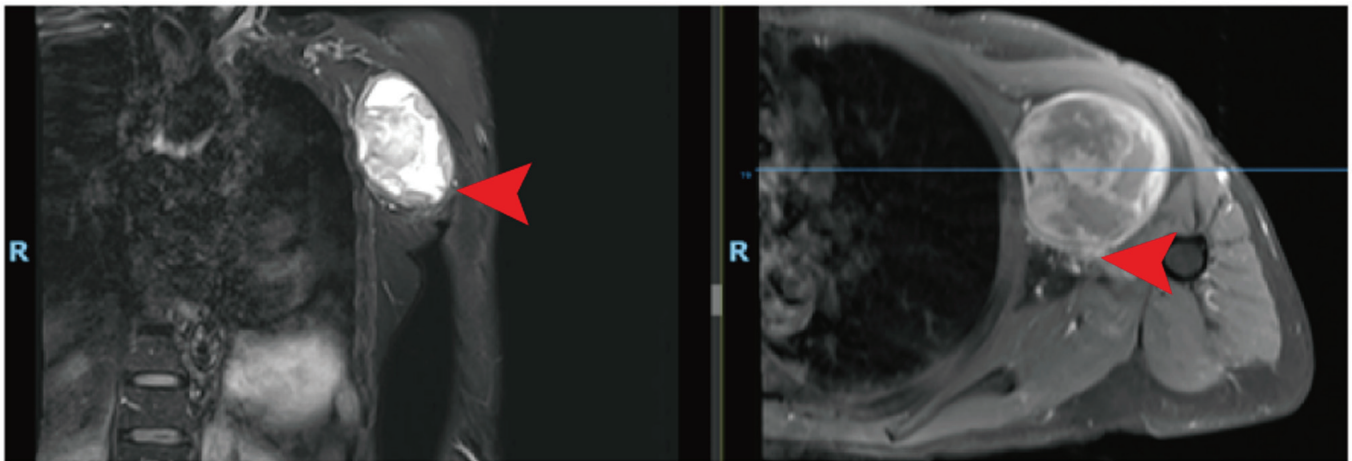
Magnetic resonance imaging was used to identify a left axillary lesion measuring 5.7x5.7x7.7 cm, from which a diagnosis of a nerve sheath tumor was initially suspected; the arrows indicate the tumor.
